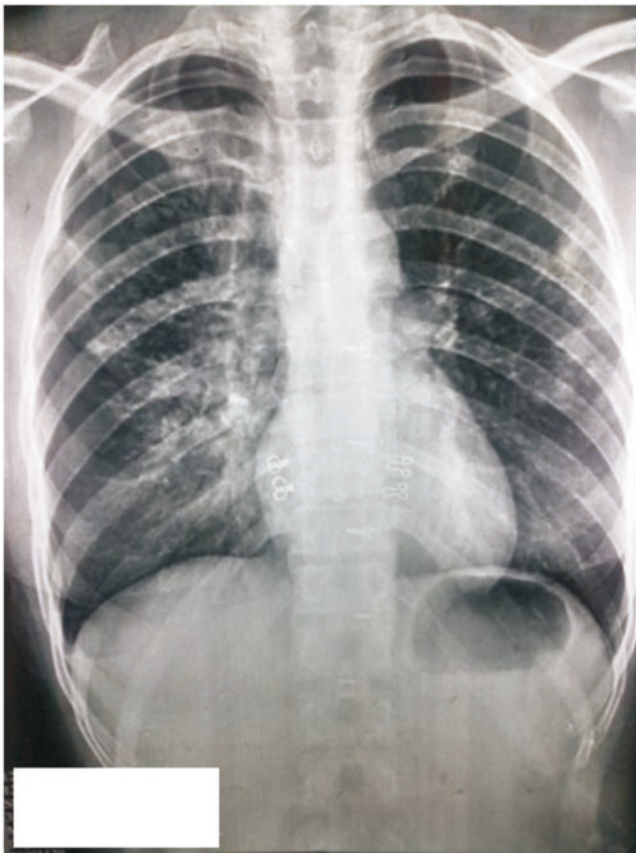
Chest radiograph posterior view at presentation (baseline).
